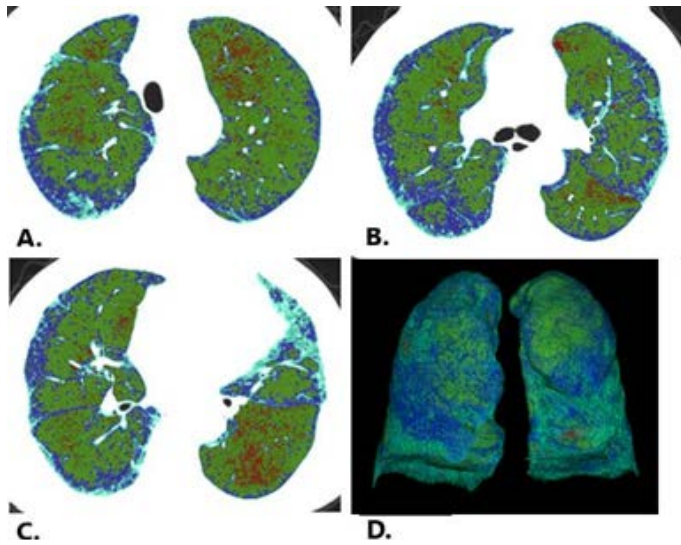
Grade 1: Automated Lung Density Color Mapping. Axial CT images obtained (A) 5 cm above the tracheal bifurcation, (B) at the level of the tracheal bifurcation, and (C) 5 cm below the tracheal bifurcation, with (D) three-dimensional volume rendering. Density-based color classification according to HU intervals: red, emphysema (-1000 to -950 HU); green, hyperinflation (-949 to -850 HU); blue, normal parenchyma (-849 to -700 HU); light blue, hypoventilation/consolidation corresponding to fibrosis-like changes (-699 to -200 HU).
